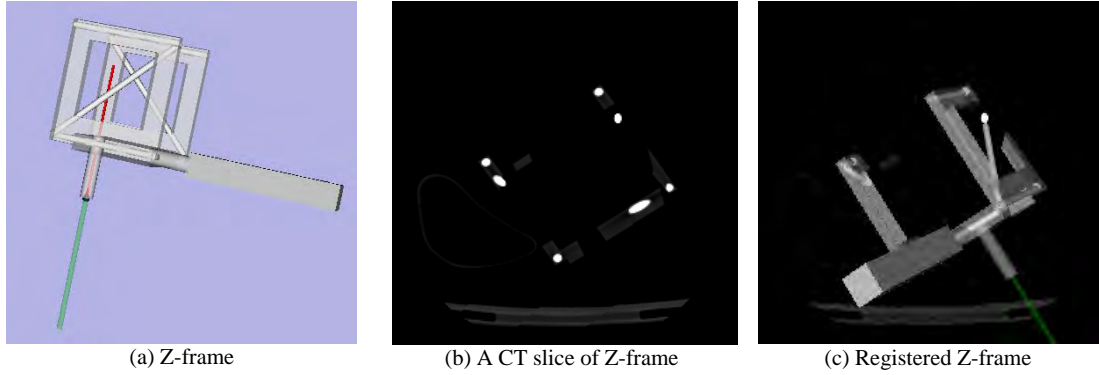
Registration of Z-frame to CT
